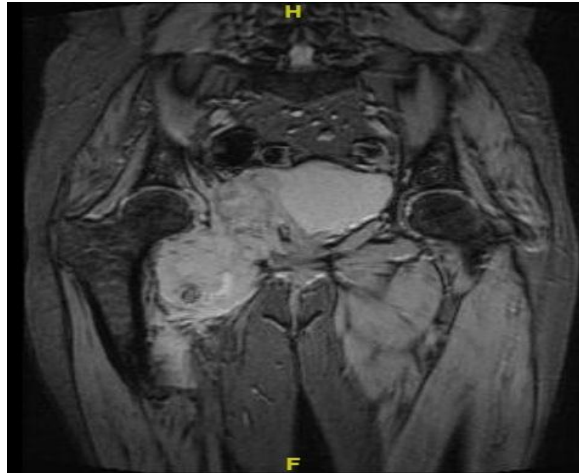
MRI showing the lesion involving right lateral wall of bladder and adductor compartment of right thigh
